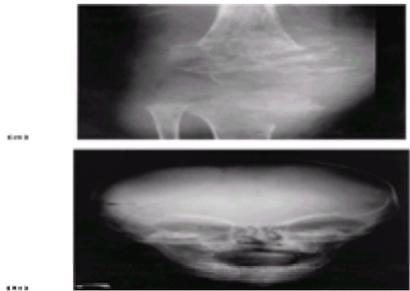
Metastatic neuroblastoma in a 2-year-old boy with intense knee pain. (a) Radiograph of the knee. Extensive osteolysis and periosteal bone reaction. (b) Radiograph of the skull. Osteolytic area in the right parietal bone.
